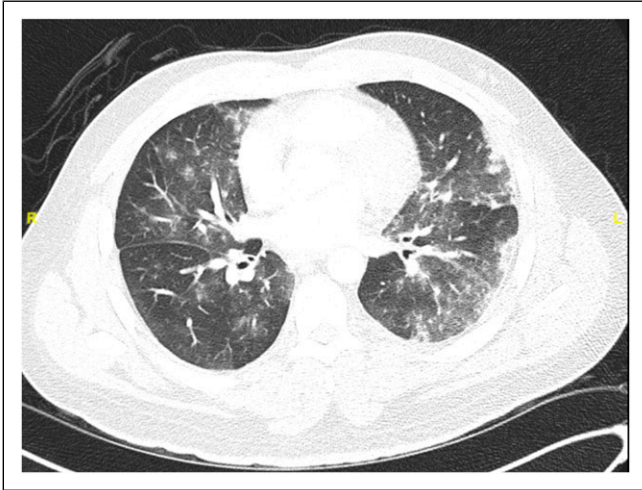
Computed tomography findings in case 3.
